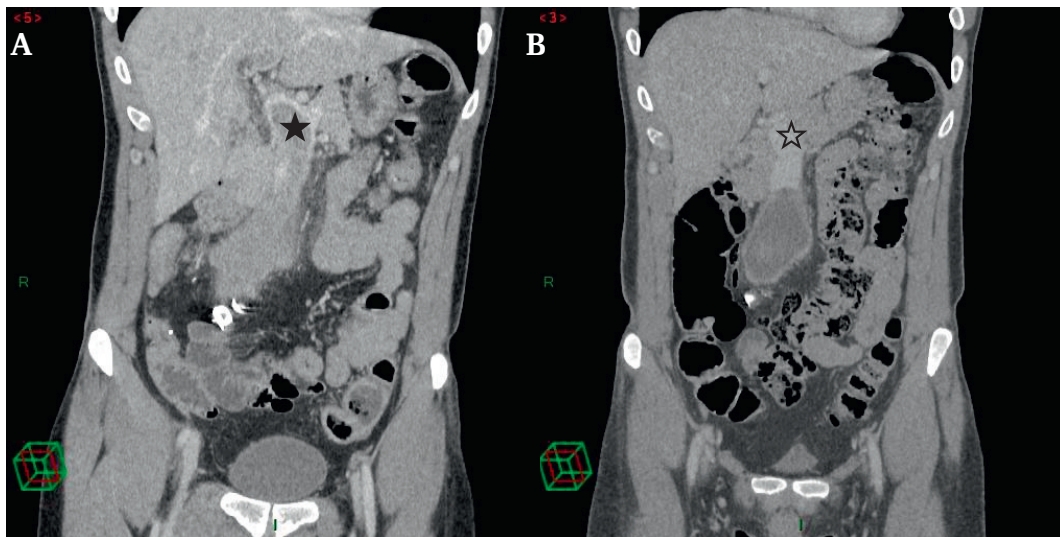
Post-operative computed tomography. (A) Thrombosis of the superior mesenteric vein, extending to the portal vein (★). (B) At three months, reduction in size of the thrombus and limited to the superior mesenteric vein. Patency of the portal vein (☆).
